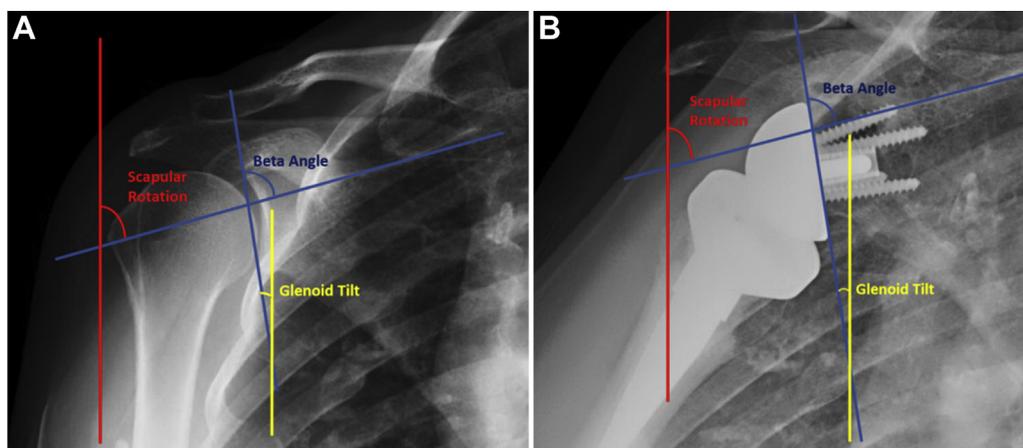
Preoperative and postoperative radiographs with representative measurements. (A) On this preoperative radiograph, the β angle and scapular rotation are measured using the supraspinatus fossa as a reference line. Glenoid tilt is measured as the angle between a line from the superior-to-inferior glenoid and a vertical plumb line. (B) Postoperative radiograph with similar measurements.
